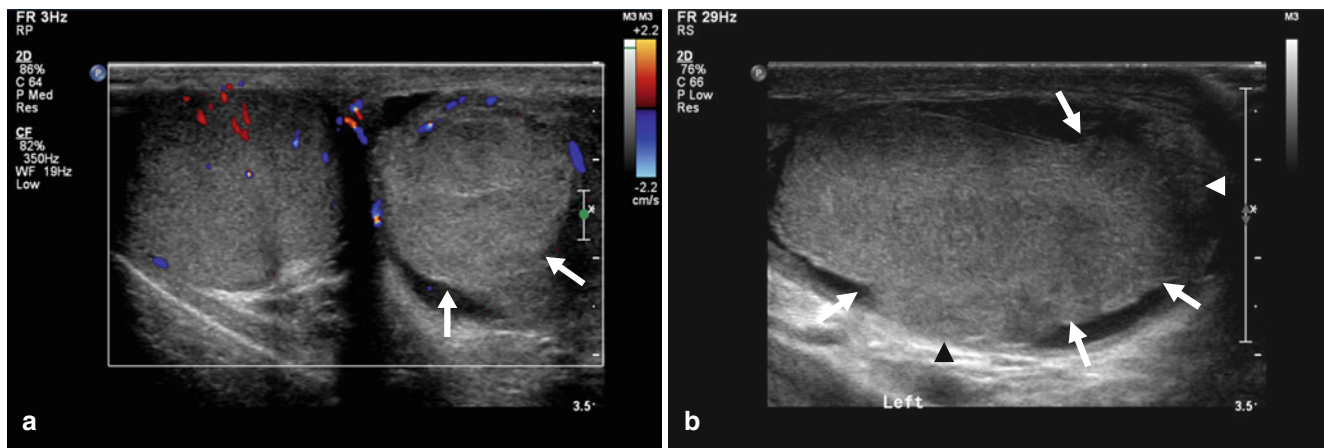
Testicular rupture in a 12-year-old boy with scrotal trauma. Color Doppler image (a) shows slightly decreased echogenicity and decreased color flow in left testis. Longitudinal US (b) demonstrates
